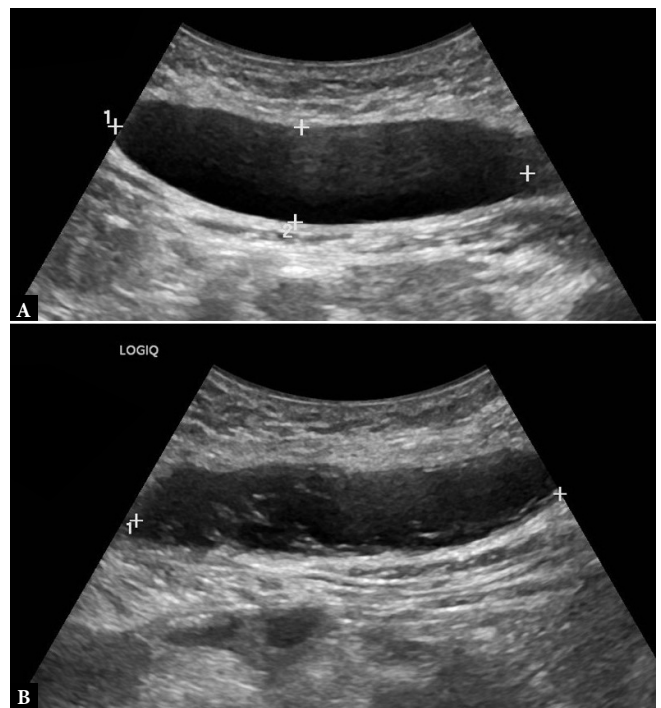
Ultrasound of the abdominal wall demonstrating a right-sided anechoic subcutaneous collection consistent with a postoperative seroma (A) and a left-sided collection with internal echogenic strands and particulate content consistent with a hematoma (B)
